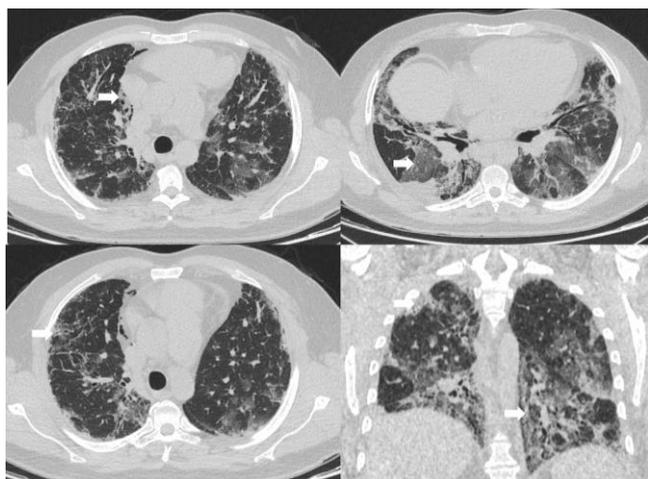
Chest CT scan revealing bleomycin induced lung toxicity, diffuse lung fibrosis, multifocal ground glass opacities with peribronchial cuffing, and cylindrical bronchiectasis (arrows). This CT scan showed no pneumothorax or pneumomediastinum
